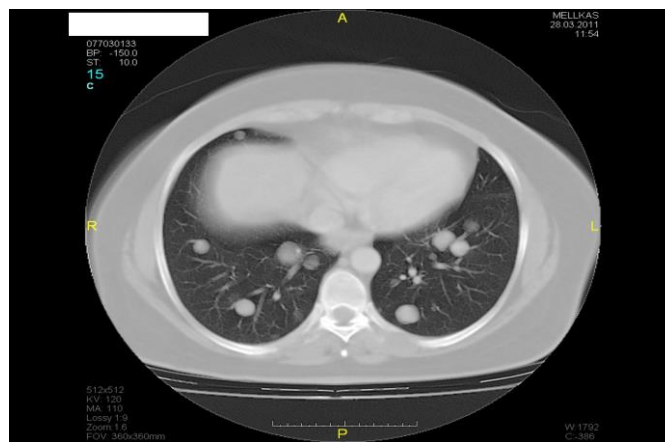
Contrast enhanced chest CT with BML lesions in both lobes
